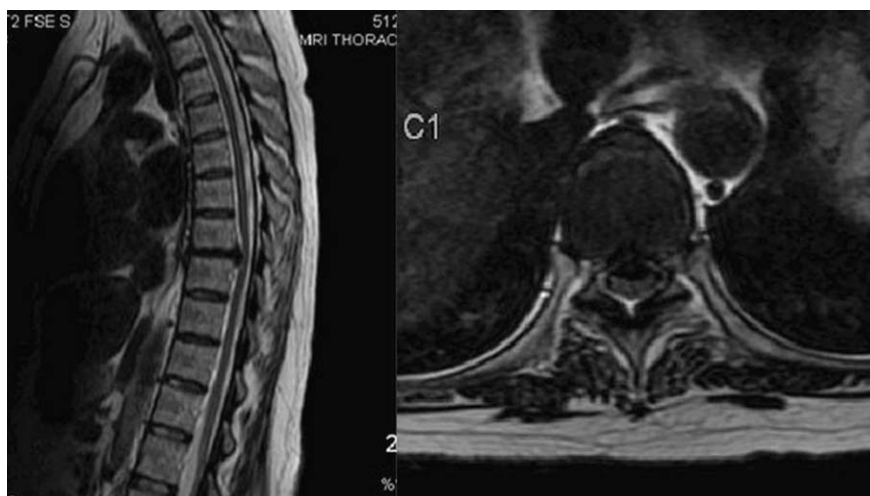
Preoperative sagittal (*left*) and axial (*right*) MRI showing a centrally herniated calcified T7-8 thoracic disc.
